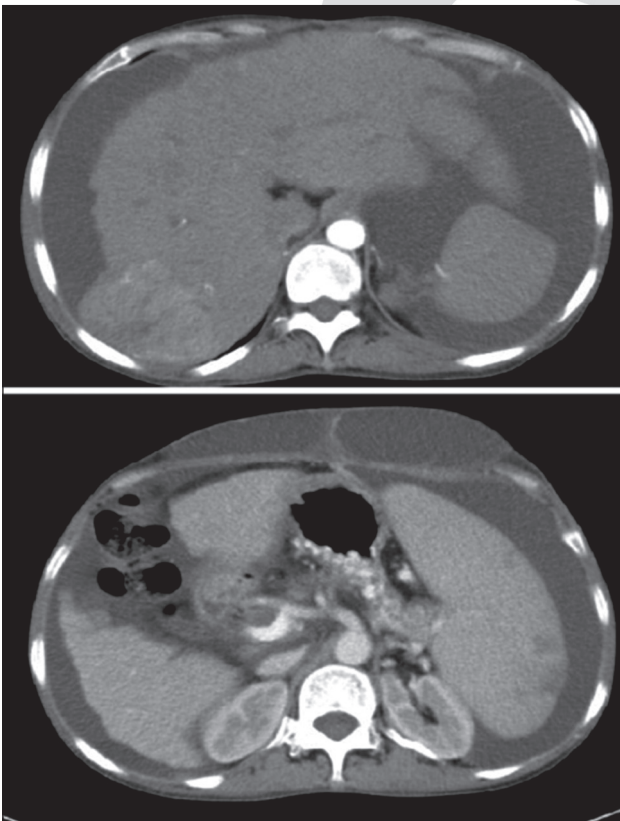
Abdominal contrast-enhanced CT images. 2A:CT in the arterial phase demonstrates a high attenuation region in the location of segment VII. 2B:CT in the portal phase showing incisional hernia and signs of portal hypertension.
